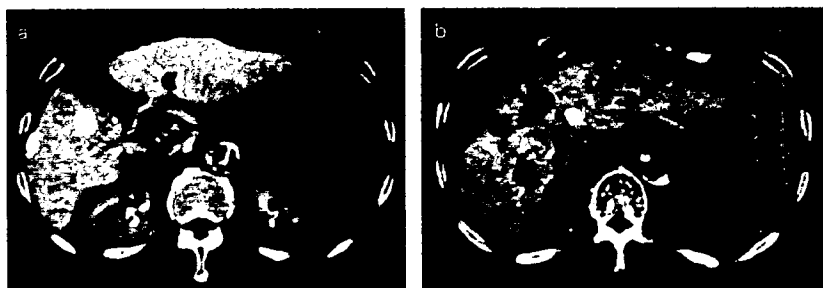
(a, b) Recurrent HCC in a 56-year-old man. Computed tomography images appear similar to those in Figure 3; however, all three tumor markers were elevated in this patient, and he died within 5 months of this imaging examination.
